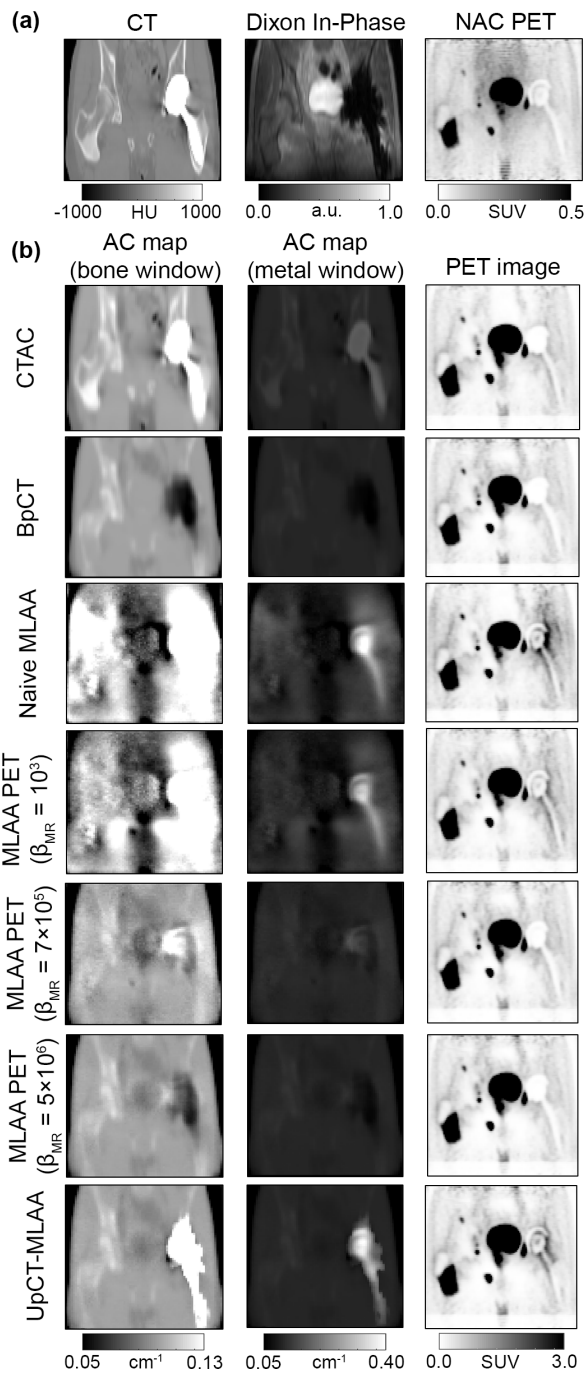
Representative images from metal implant patient #1 imaged with  $^{68}\text{Ga}$ -PSMA. Shown are the CT, Dixon in-phase, and NAC PET images (a), AC maps (b, first and second column), and associated PET reconstructions (b, third column). The AC maps are shown in two different window levels to highlight bone and soft tissue (b, first column) and the metal implant (b, second column).
